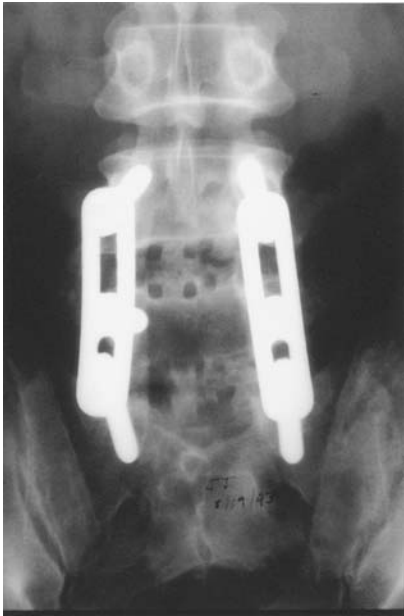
One-year postoperative AP x-ray. Bone inside the left-sided cage has consolidated; however, there is some resorption of bone inside the right-sided cage at L4-5. (From Ref. 33.)
